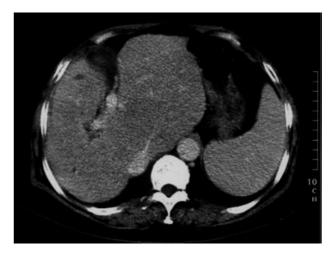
Computed tomogram taken 2 months after caudate lobe-sparing subtotal hepatectomy showing further hypertrophy of the caudate lobe with no evidence of residual stones or dilated ducts
